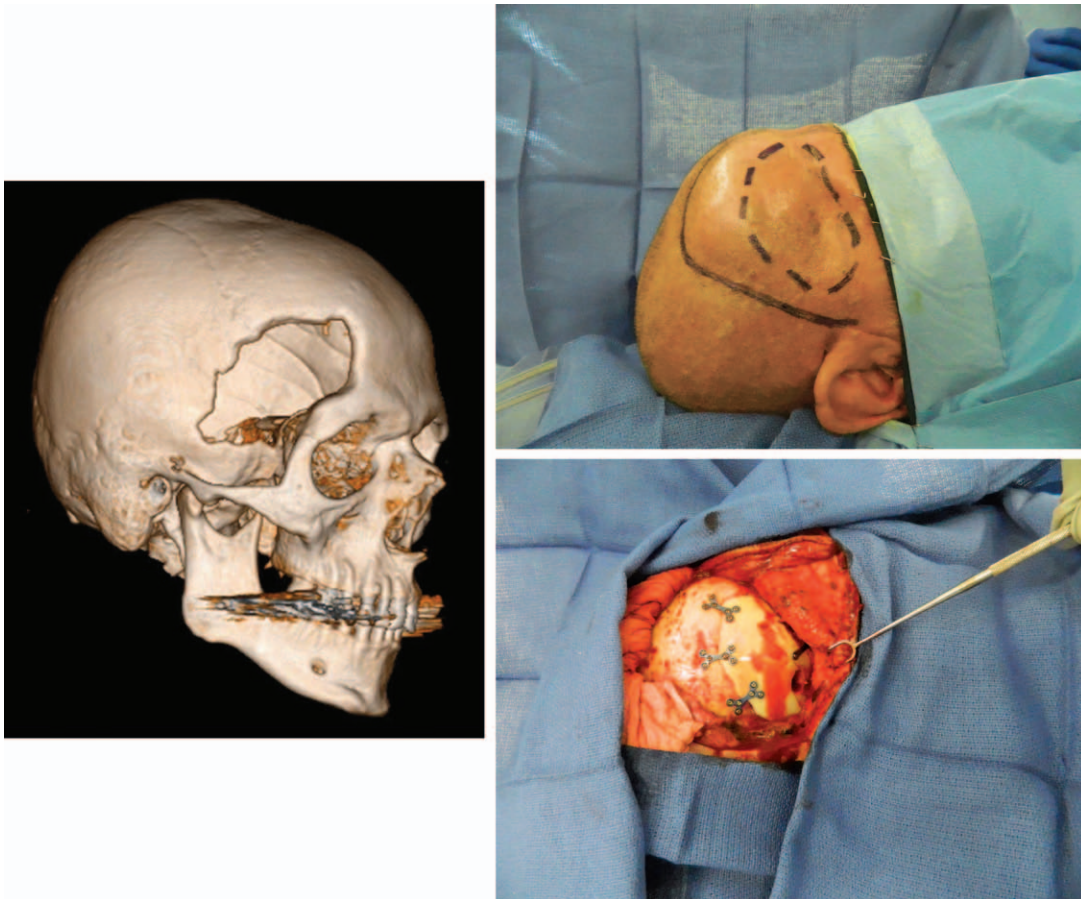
Preoperative three-dimensional computed tomography scan on right oblique view shows large, right-sided, frontotemporoparietal skull defect (*left*). Intraoperative photograph demonstrates well-healed neurosurgical incision (*solid marked line*) and underlying skull defect requiring cranioplasty (*dotted marker line*) (*above, right*). Intraoperative photograph showing customized cranial implant in place with rigid fixation and pericranial-onlay cranioplasty technique (*below, right*).
